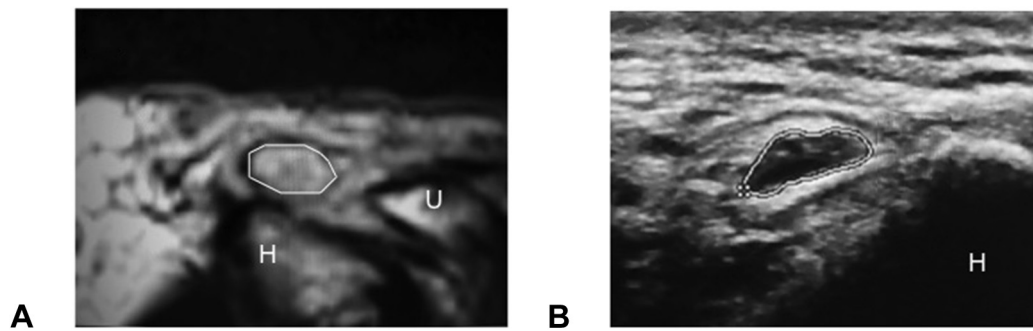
Cross-section of the ulnar nerve at the ME level by A T2-weighted axial MRI and B US imaging. H, humerus; U, ulna. Both images are oriented with the superficial layer at the top and the deep layer at the bottom (magnifications $\times 4.00$).
